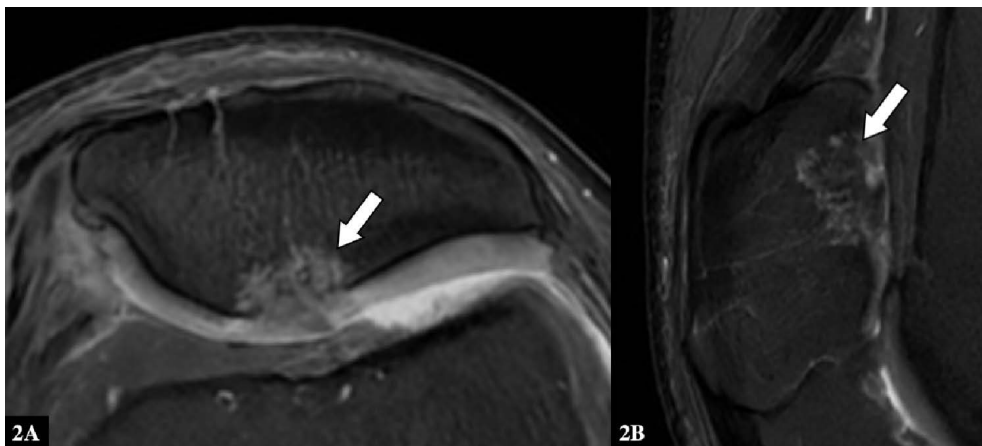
The same 58-year-old male after patellar ridge repair. FINDINGS: Initial post-operative unenhanced MRI of the left knee showing ingrowth of the patellar repair patch (arrow) into the curetted subchondral bone, with surface congruent with the native articular cartilage. TECHNIQUE: 2a) Axial proton density fast spin echo fat suppression sequence on 3T, 2b) Sagittal oblique T2-weighted fat suppression sequence on 3T.
